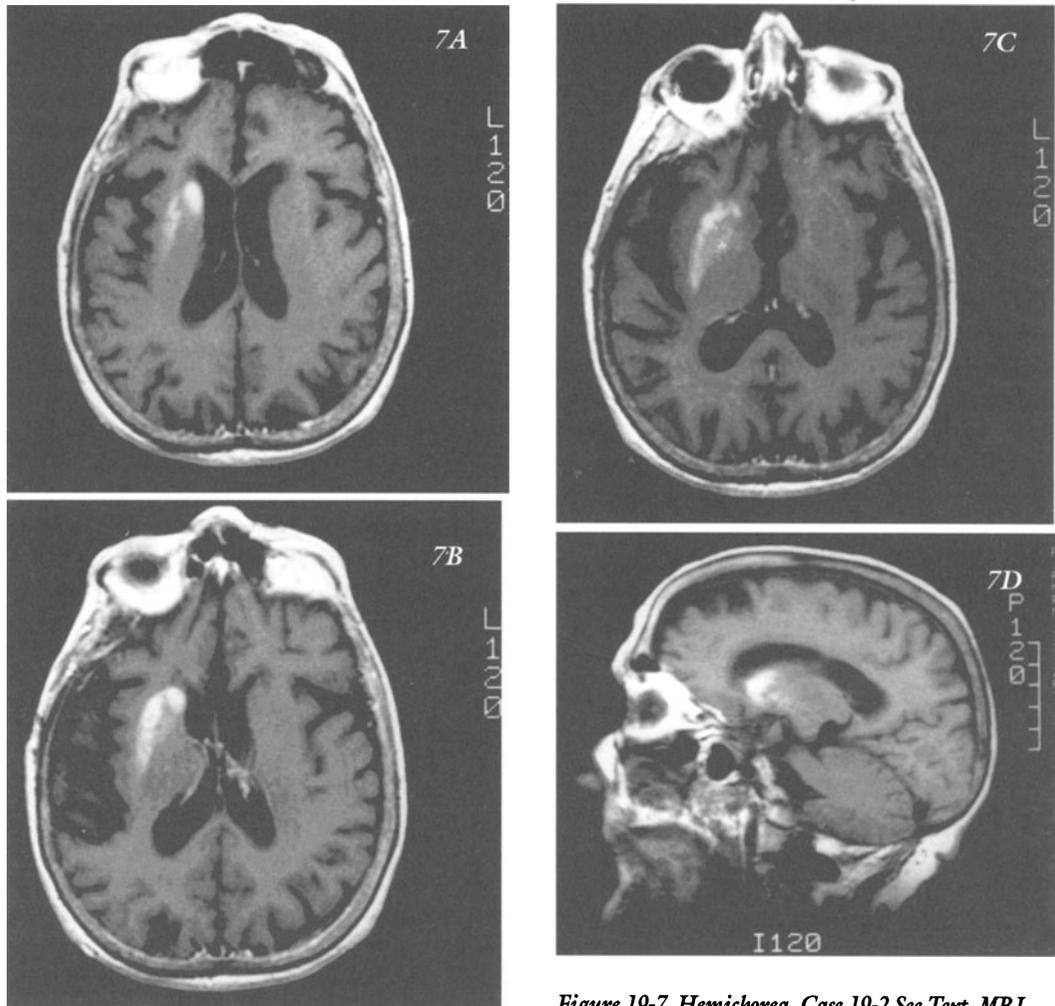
Hemichorea. Case 19-2 See Text. MRI demonstrates a hyperdense area of the head of the right caudate, adjacent putamen and external capsule - consistent with a hemorrhage. A, B, C - sequential horizontal sections at 5 mm. intervals - T1; weighted D - Sagittal section 12.5 mm to right of midline.
